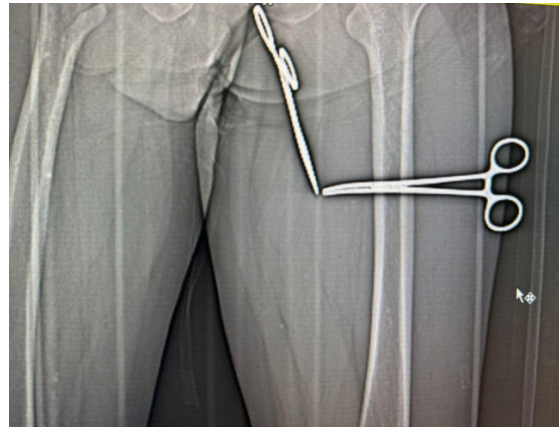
CT scannogram planning shows precise localization of a hyperdense foreign body.
